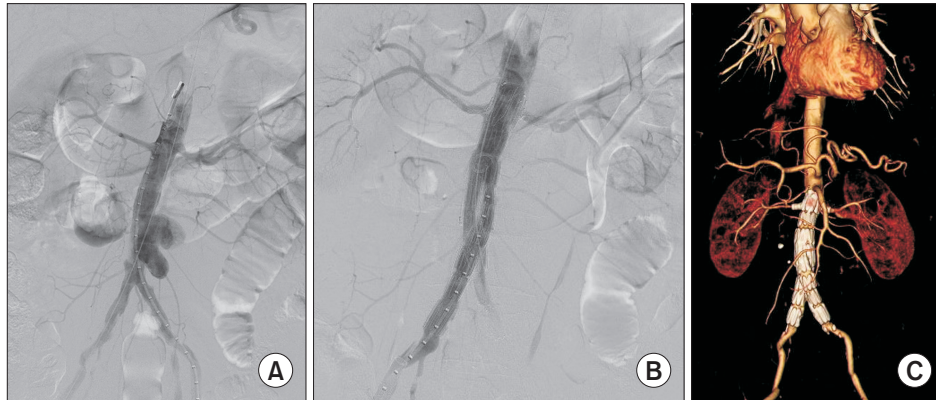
(A) A case of ruptured 51-mm mycotic infrarenal abdominal aortic aneurysm. (B) The patient was treated with 2 renal fenestrations for both renal arteries. (C) Follow-up CT reconstruction demonstrates patent endograft with flow through both renal arteries.
